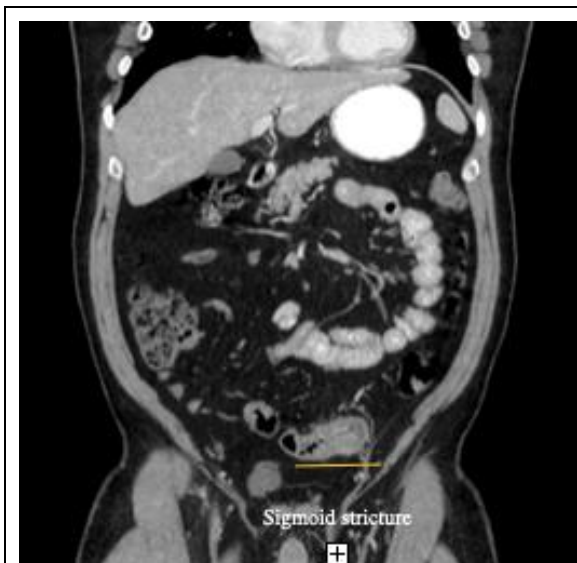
Abdominal CT showing stricture in sigmoid colon.
